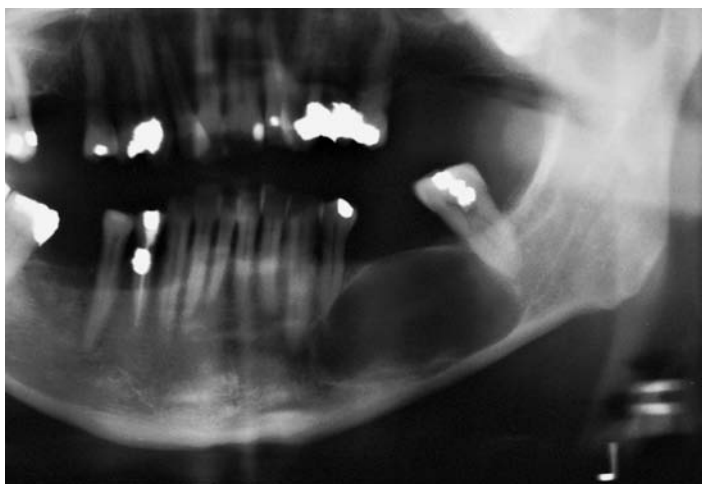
Radiograph of a residual cyst. The lesion is at the site of a previously extracted tooth. The lesion must be differentiated from a keratocyst.
